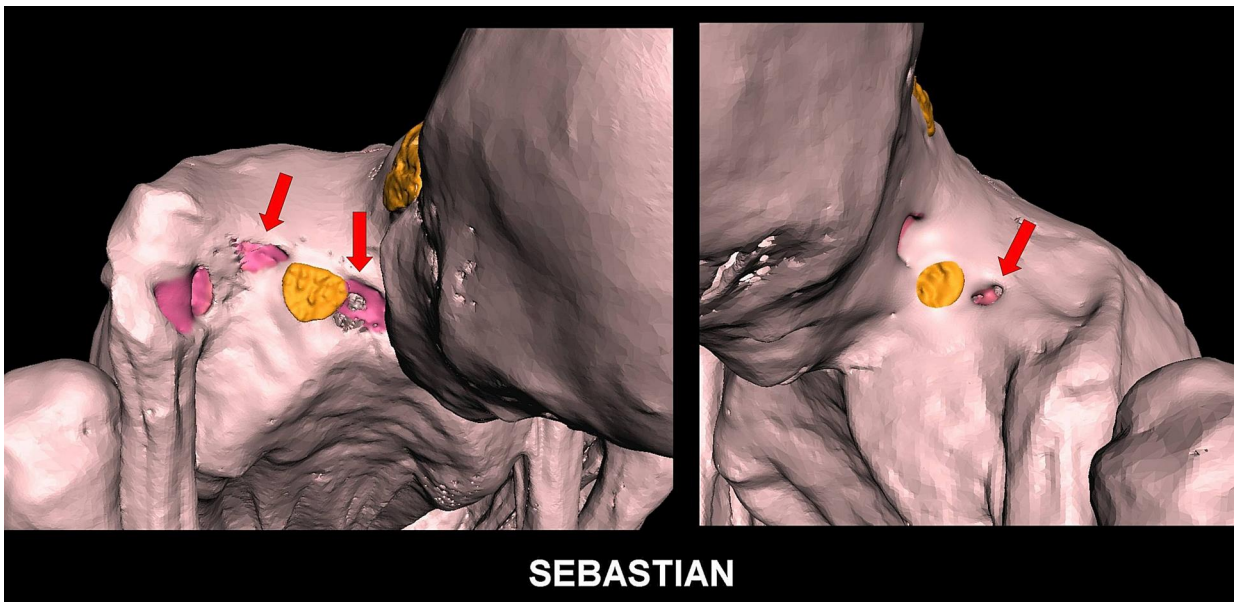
3D CT showing tissue loss (*red arrow*) over right supraclavicular area (*left*). Puncture wound (*red arrow*) was noted lateral to metallic implant in left supraclavicular area (*right*).
